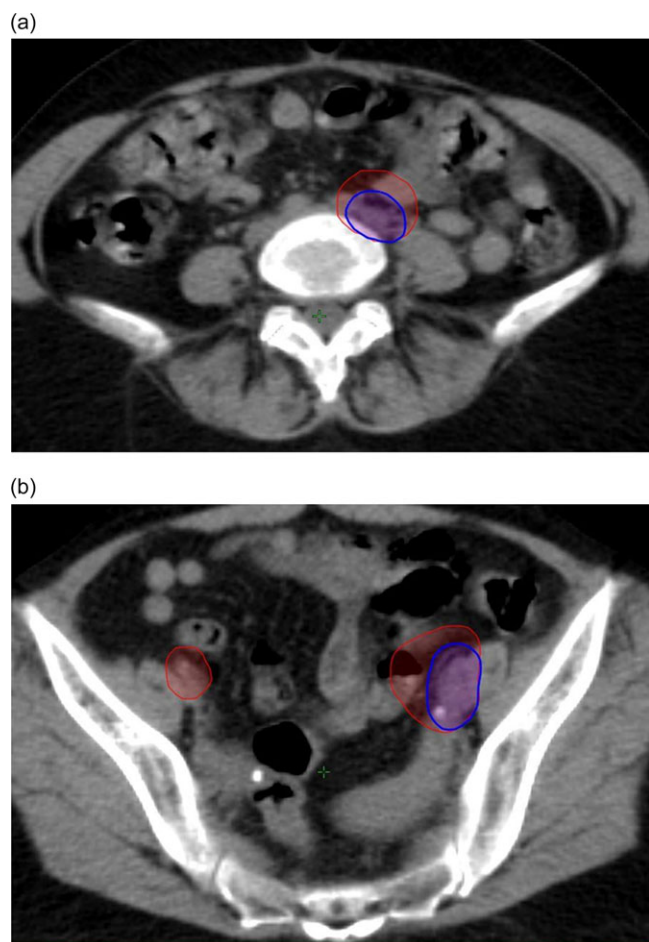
(a, b) Two examples of nodal shrinkage during the course of radiation and the movement of bowel inside the PTV-SIB. The contour in red shows the representation of PTV-SIB on the CT dataset 2, while the PTV-SeB is shown in blue
